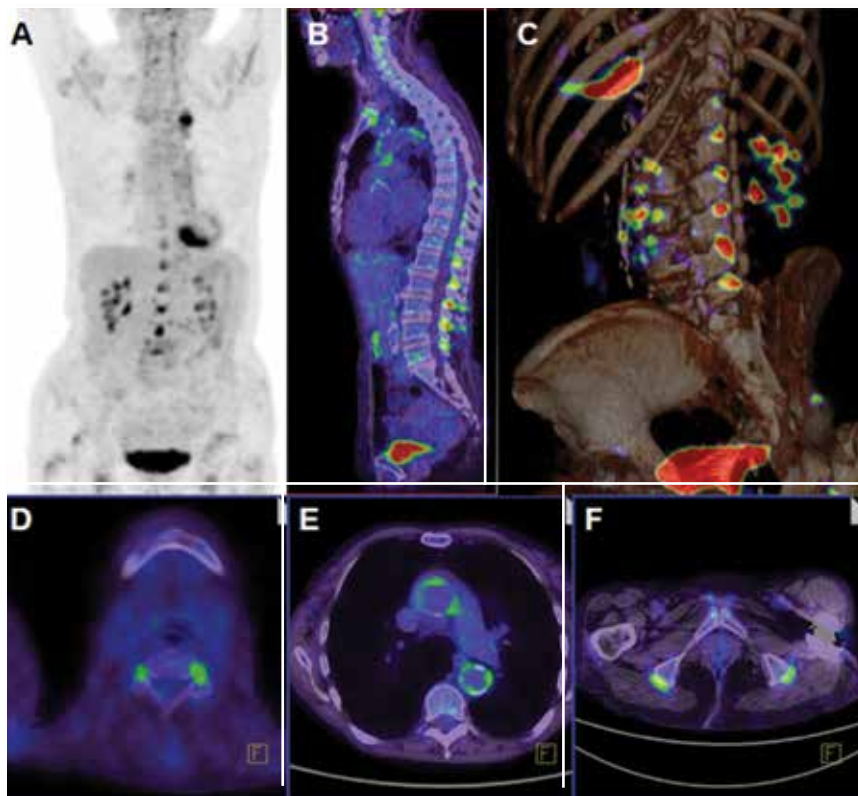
Fluorodeoxyglucose positron emission tomography (PET)/CT scanning in a patient with unsuspected polymyalgia rheumatica.¹⁹ a (top, left). Maximum intensity projection image providing a whole-body overview. b (top, middle) and c (top, right). Coronal and three-dimensional PET/CT bone scans showing interspinous bursitis. d (bottom, left) and e (bottom, middle). Vasculitis of large and medium-sized vessels, with high uptake in the aortic arch and great vessels. f (bottom, right). Widespread bursitis and enthesopathy.
